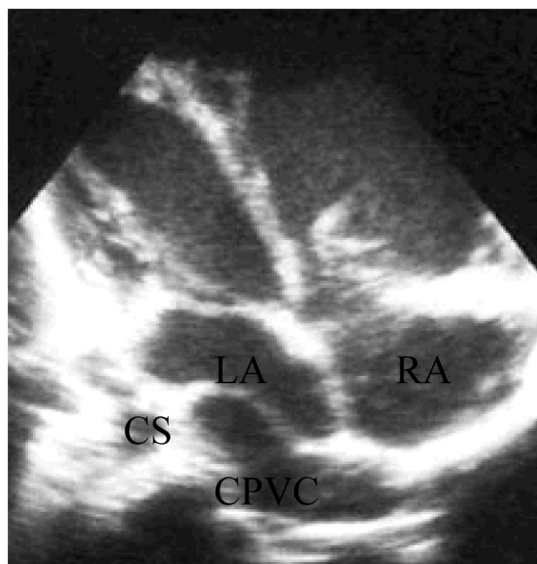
The dilated coronary sinus (CS) and common pulmonary venous confluence (CPVC) above the left atrium (LA) on transthoracic echocardiography (apical 4-chamber view). RA indicates right atrium.
